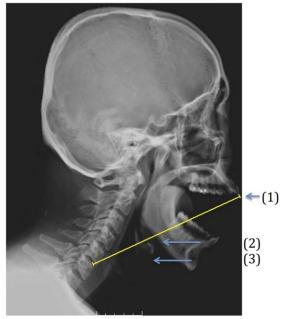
Unfavorable airway trajectory measurement (ATM). Standard 72-inch lateral neck x-ray, taken in the sniffing position with the mouth opened widely, demonstrating an unfavorable airway trajectory measurement. Maxillary incisors (1), vallecula (2), and larynx (3) are as labeled. A linear projection is drawn from (1), through (2), and projects posterior to the larynx (3). [Color figure can be viewed in the online issue, which is available at www.laryngoscope.com.]
